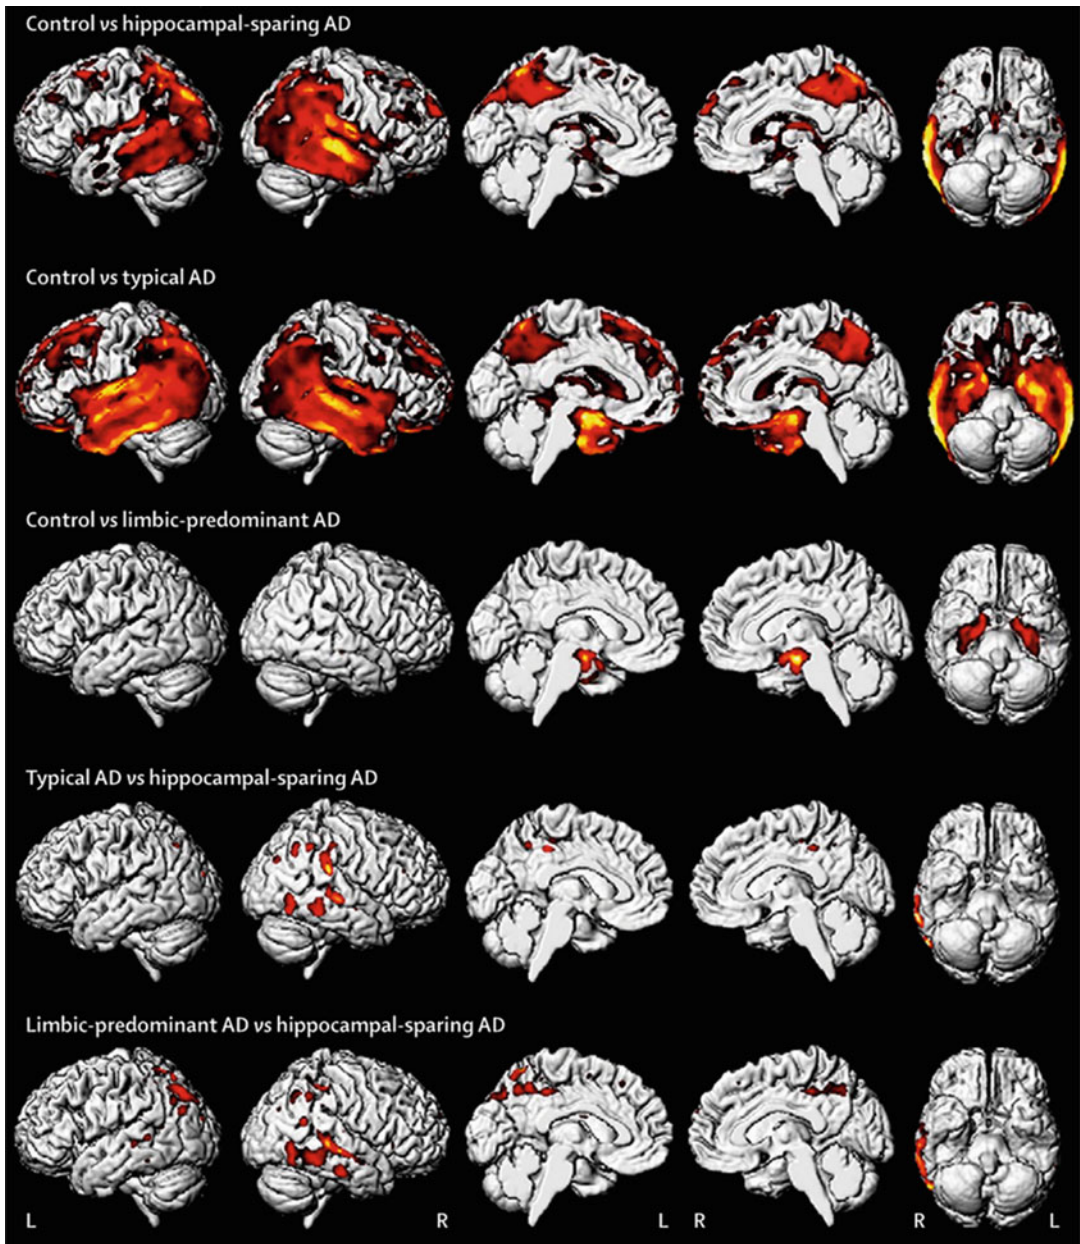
Atrophy patterns in MRI in different variants of AD. Patients with hippocampal-sparing AD showed greater cortical loss than did those with typical and limbic-predominant AD, predominantly in the posterior temporal lobe, the inferior parietal lobe, and the precuneus; greatest loss was noted in the right hemisphere. Results are
